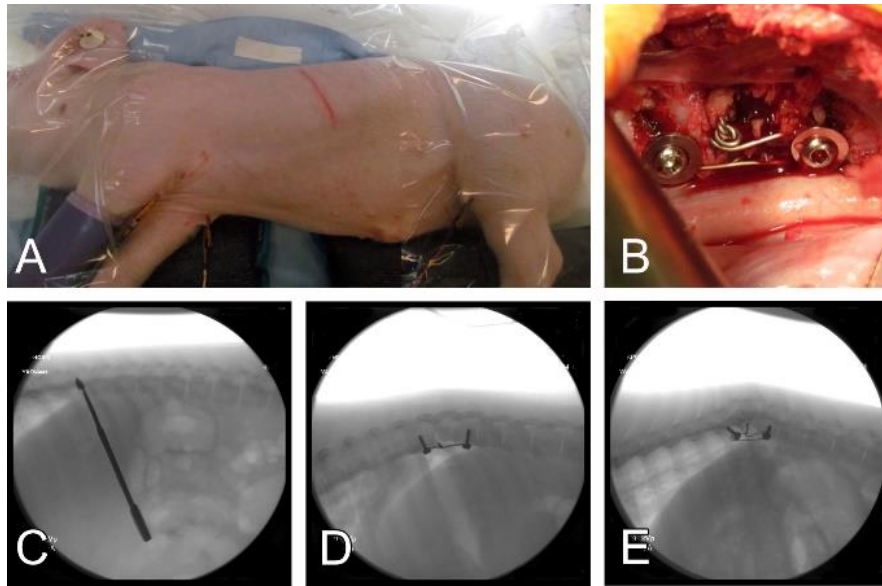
A) Site of thoracotomy between ribs T10-T11. Exposure of the spine, placement of screws and partial resection of T10 vertebral body. B) Wire loop placed around screws and tightened. Radiographic imaging. C) Approximately 8° T9-T11 Cobb angle pre-op, D) 30° post-op, and E) 41° at follow-up prior to corrective surgery.
